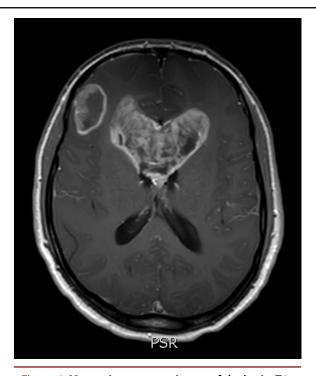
Magnetic resonance image of the brain, T1 with contrast, axial view showing a heterogeneous mass centred in the genu of the corpus callosum with (widest diameter, 6.3 cm) and a smaller mass in the right superior frontal lobe (diameter, 3 cm)
